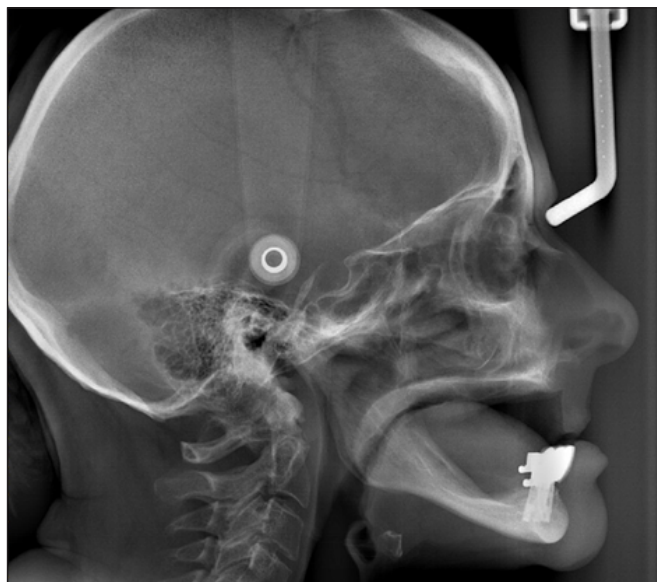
Cephalometric view. Radiographic view of the inter-maxillary relationships prior to the surgical procedure.
